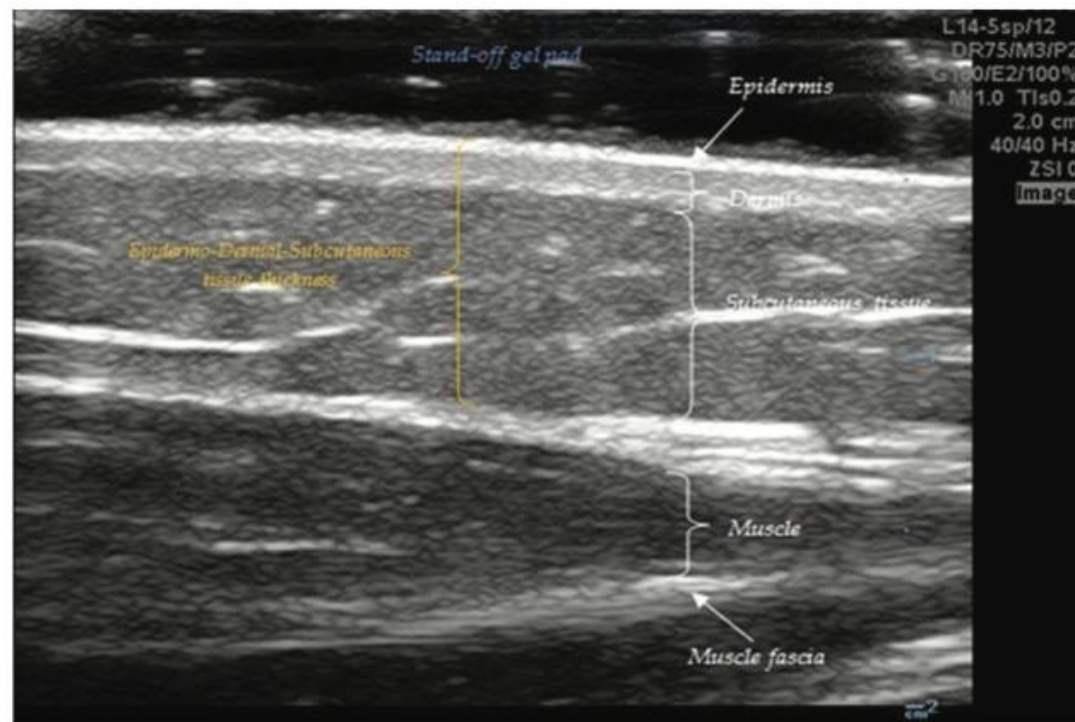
Normal skin ultrasound/measurement of epidermal-dermal-subcutaneous tissue thickness (skin elevation).
